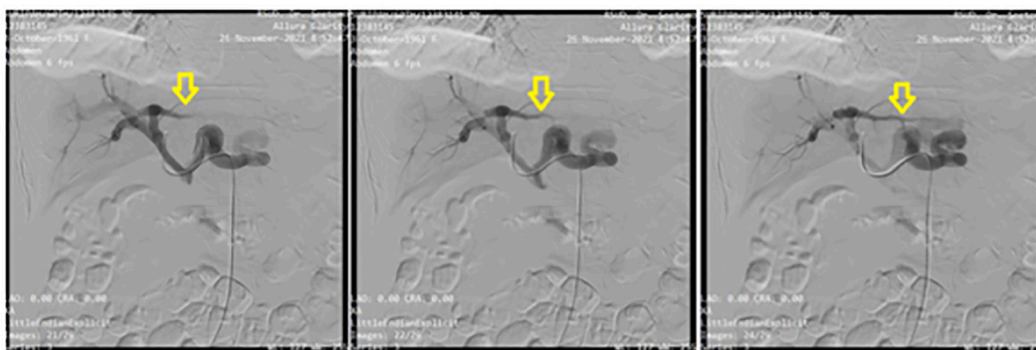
CTA revealed right hepatic artery fistulation to the portal vein.
